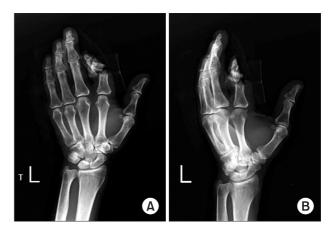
Preoperative view. A plain radiograph showing crushing amputation of the index finger through the proximal interpharyngeal joint. (A) Anterior-posterior view. (B) Oblique view.
